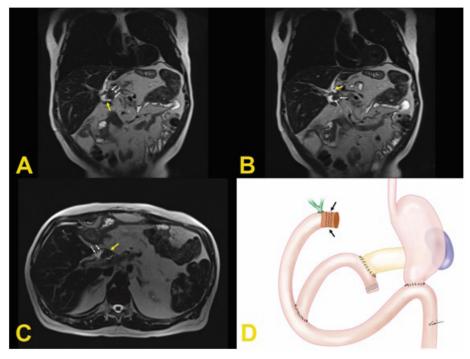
MRI shows hepatico-jejunostomy intussusception
